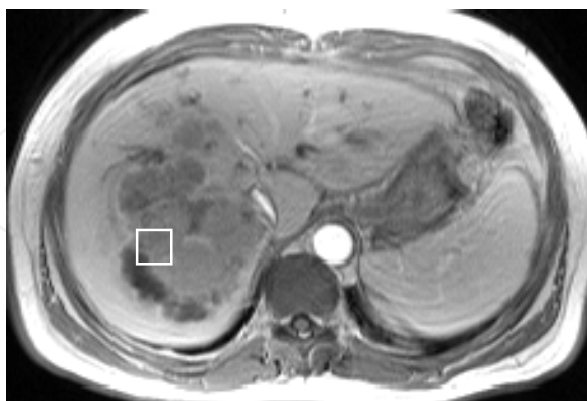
12×12 ROI block drawn on suspected liver tumor in a MR image of the abdomen. Liver tumor has irregular shape and has multiple growths tissue.
